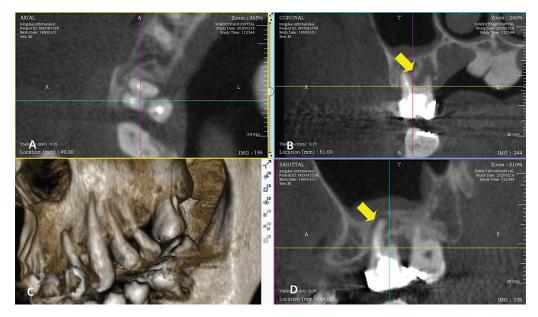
CBCT of case 3. (A) axial view, (B) coronal view, (C) reconstruction view and (D) sagittal view.
